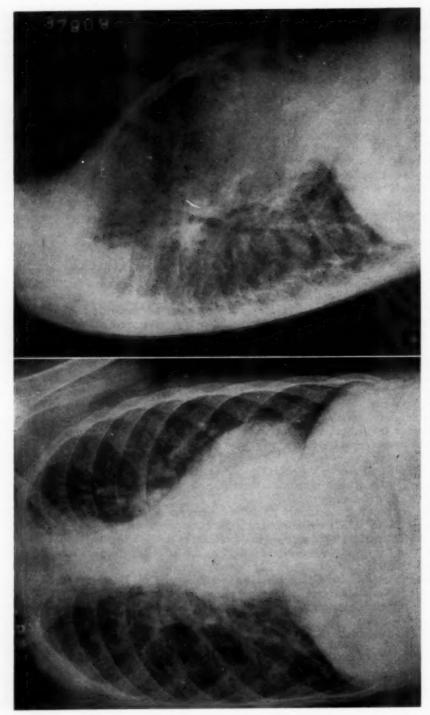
Roentgenogram of chest in case of transposition of the great vessels (complete).
